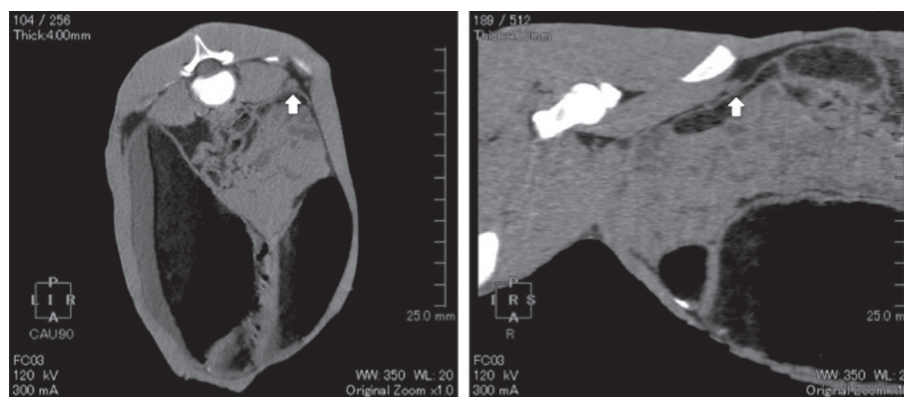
Computed tomography images of Case 3 in axial (left) and sagittal (right) planes. Arrow indicates the cryptorchid testis.
